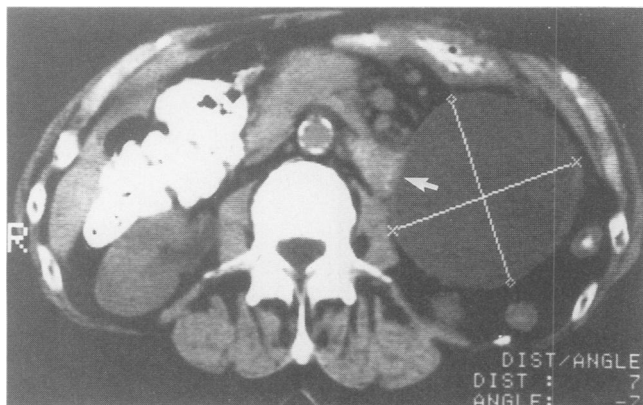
Computed tomographic scan of an unresectable mucinous cystadenocarcinoma. A component of solid tumor is seen to the left of the cyst (arrow). Cytologic examination of a percutaneous aspirate showed malignant cells.
